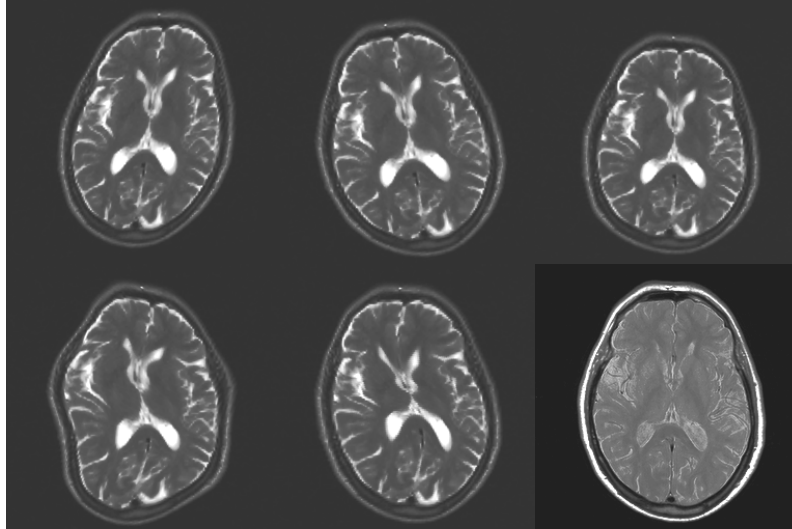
(b): For inter-modality registration, synthetically deformed T_2 -weighted MR images acted as the reference. Five types of deformation were used (counterclockwise from top right): thin plate spline, rotational, bilinear, rotational, sinusoidal, and Gaussian. A proton density MR image (bottom rightmost) was taken as the floating image.
